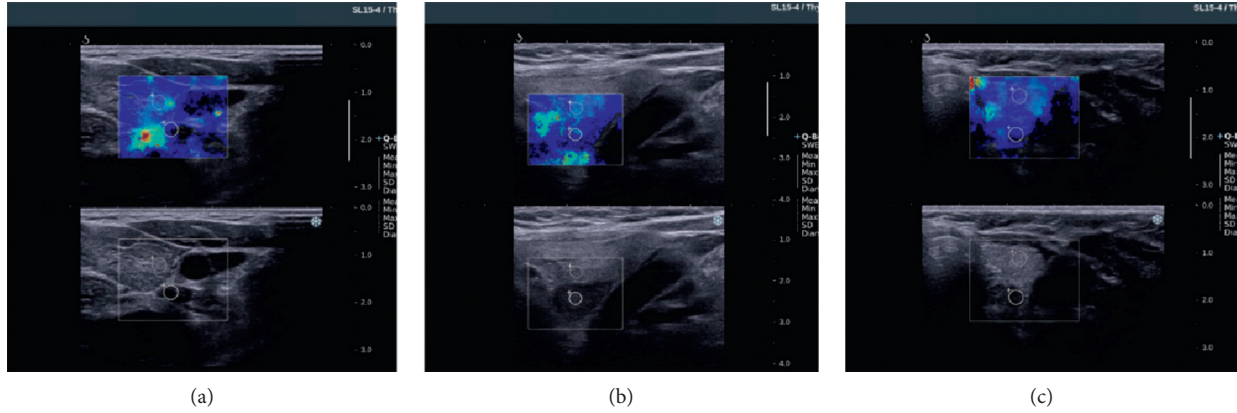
Image (a) –ultrasound appearance of hypoechoic cystic nodule; (b) –ultrasound appearance of hypoechoic homogeneously solid nodule; (c) –ultrasound appearance of mixed nodule.
